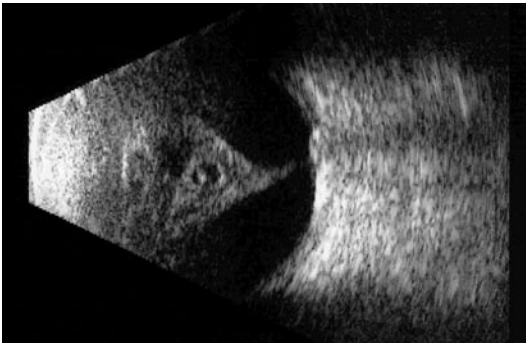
Ultrasonography of a severely injured eye: PVD or a retinal detachment? The interpretation of the test in this 9-year-old boy who sustained a rupture was “total retinal detachment inserting on the optic nerve; retina very thin at insertion.” During surgery, no retinal detachment was found after the vitreous hemorrhage had been removed
